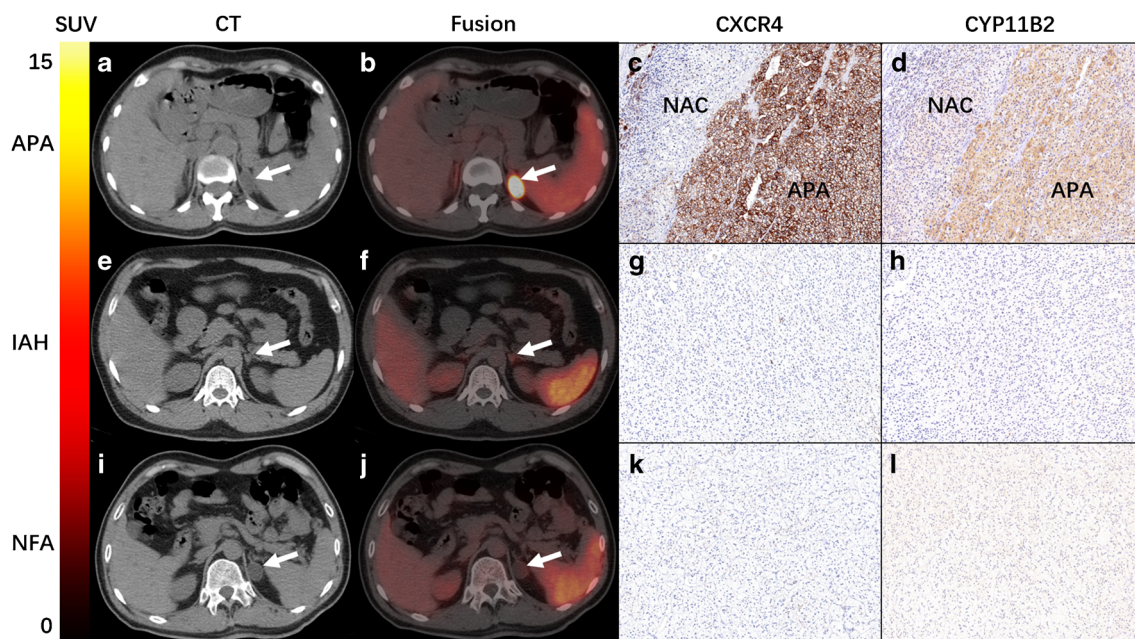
A–D Representative ^{68}Ga -pentixafor PET/CT of a 44-year-old female patient who presented with general malaise and hypertension. The level of serum potassium was 2.2 mmol/l. A true positive uptake (SUV_{max} 36.4, white arrow) was observed in one APA lesion (adrenocortical adenoma) and NAC normal adrenal cortex with strong expression of CXCR4 and CYP11B2 (C–D). CT demonstrated a 2 × 2.3 cm lesion with intense uptake in the left adrenal gland. The patient's blood pressure and serum potassium returned to normal range after surgery. E–H Representative ^{68}Ga -pentixafor PET/CT of in a 26-year-old male patient. ^{68}Ga -Pentixafor PET/CT was true negative in IAH (adrenal cortex nodular hyperplasia). The lowest
